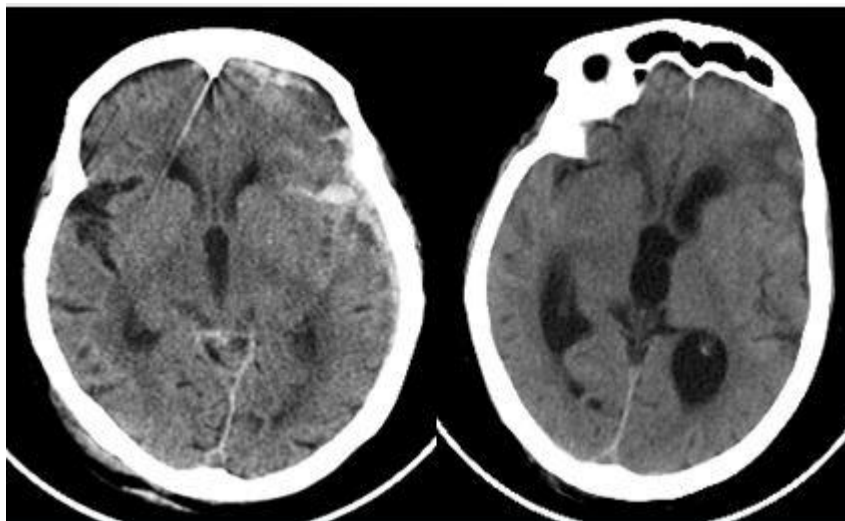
46 years male who was managed conservatively, Plain CT brain axial section at admission (left) and 24 days CT brain showing hydrocephalus(right)
